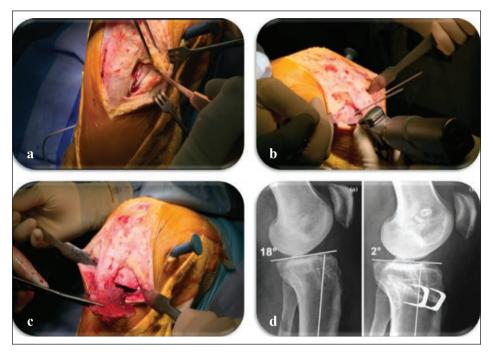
Deflexion osteotomy is performed in order to correct the PTS, reducing the ATT effect leading to the ACL graft fatigue and injury. After ACL revision, (a) the proximal tibia is exposed and (b) the osteotomy is performed under fluoroscopic control. (c) The bone fragment is removed and the osteotomy is fixed with two staples. Tibial tunnel is manually re-drilled and ACL graft passage and fixation are achieved. (d) Preoperative and post-ostoperative X-ray showing PTS correction.
